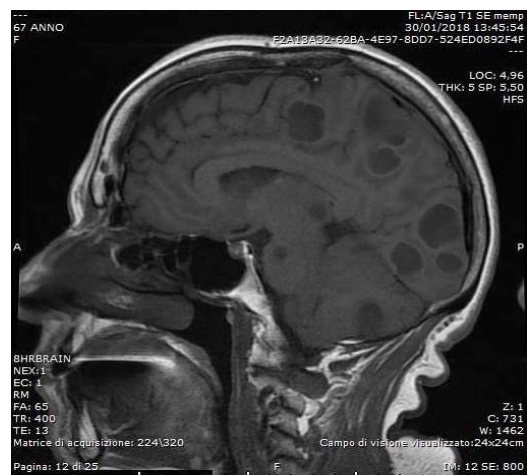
Multiple cystic lesions in sagittal T1-weighted MRI.
